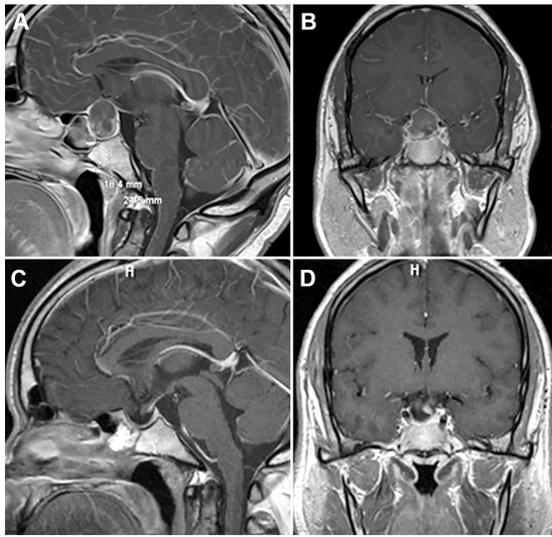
A man in the fifth decade of life experienced a sudden onset of severe headache and acute blindness. Combined trans-sphenoidal approach for pituitary apoplexy was performed. Preoperative (A) T1 sagittal and (B) coronal post-contrast MRI of the head shows large intra, para, and suprasellar hematoma with compression of optic chiasm and infiltration of cavernous sinus. Postoperative T1 (C) sagittal and (D) coronal post-contrast MRI of the head shows complete resection of the lesion with intact pituitary gland/stalk (note the small fat graft in the SS. Visual symptoms recovered following surgery (see also YouTube link).
